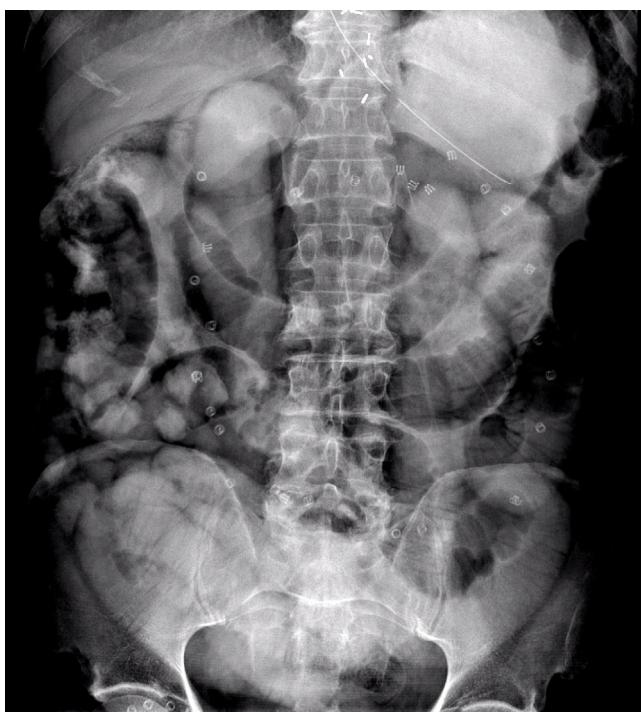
Abdominal radiograph 6 h post administration of Gastrografin.
